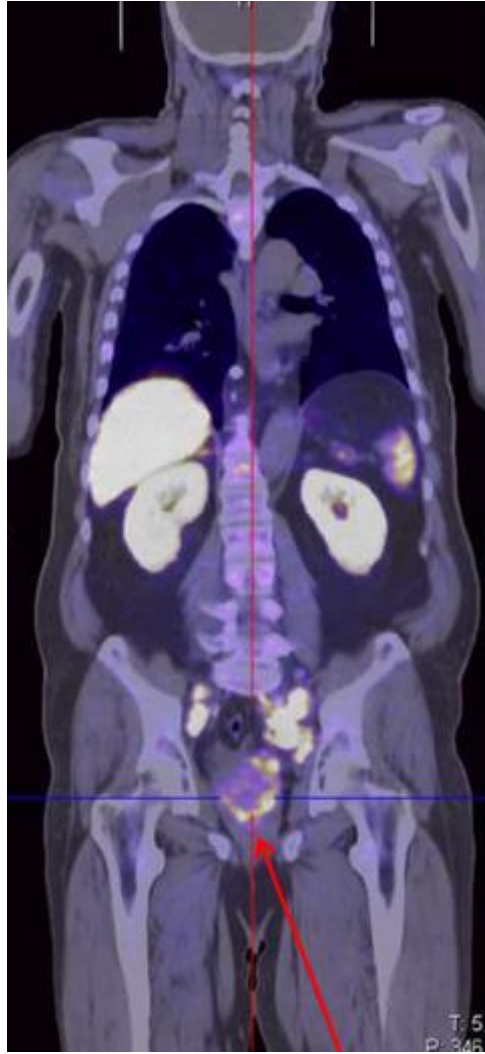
$^{18}\text{F}$ -FCH PET/CT scan showing increased tracer uptake in multiple enlarged iliac lymph nodes bilaterally (Patient at initial staging; PSA= 22 ng/mL; GS=9)
